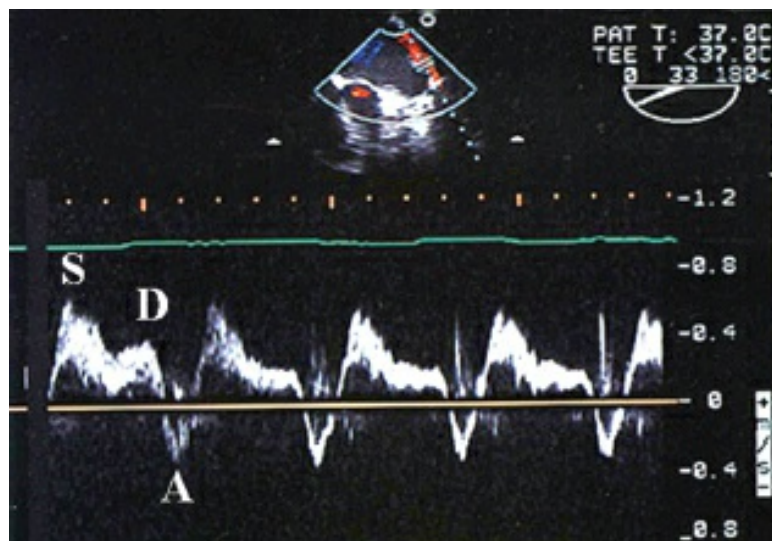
Pulsed wave Doppler from left upper pulmonary vein. Note the normal waveform (antegrade systolic S, diastolic D, and retrograde A waves).
